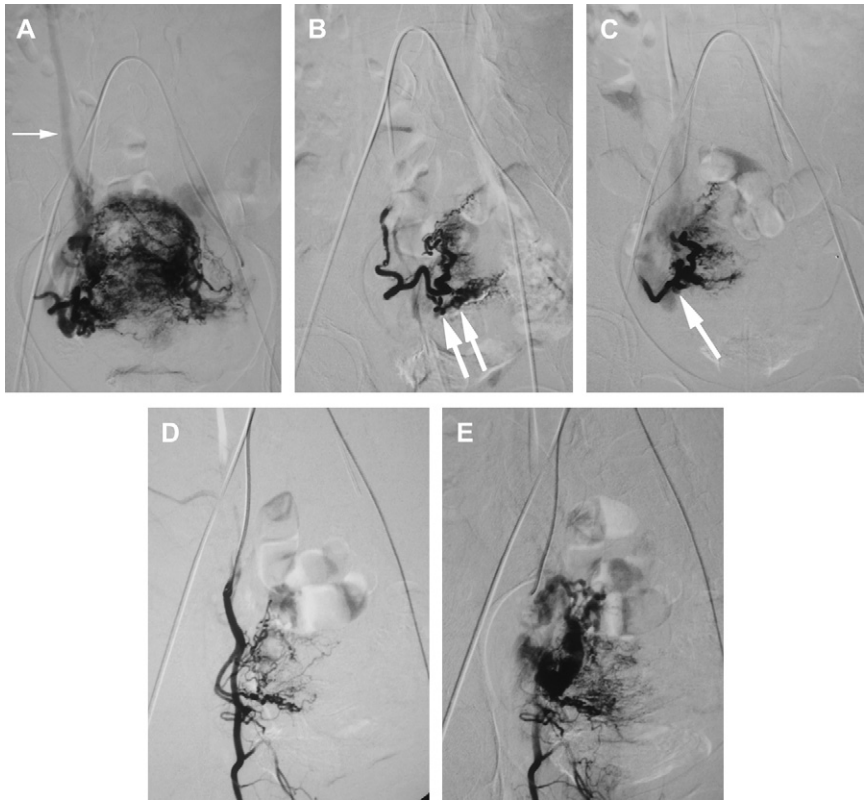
Uterine and adnexal arteriovenous malformation. (A) Twenty-four-year-old woman with recent miscarriage, dilatation, and curettage, complicated by severe bleeding and subsequent recurrent hemorrhage. Ultrasound examination showed hypervascular lesion in right cervical area with a differential diagnosis of either cervical pregnancy or arteriovenous fistula. Bilateral simultaneous anteroposterior arteriographic image reveals increased vascularity on the right uterus with an early filling right ovarian vein (arrow). (B) Right uterine arteriogram, early arterial phase in the left anterior oblique position. An enlarged cervicovaginal branch (arrows) supplied a hypervascular nidus on subsequent images. The position correlated with the cervical abnormality on duplex ultrasound (not shown). (C) Right uterine arteriogram in the left anterior oblique position after embolization. The cervicovaginal branch is occluded (arrow) and the arterial flow diminished. There is faint early opacification of veins in the right adnexae for uncertain reasons. (D) Arteriogram of anterior division of right hypogastric artery after embolization, revealing additional branches to the adnexae from other pelvic branches. (E) Late phase of arteriogram showing markedly enlarged veins extending laterally from the margin of the uterus into the adnexa. The uterine bleeding was controlled by the limited embolization of the cervicovaginal branch. The larger asymptomatic portion of the vascular malformation was asymptomatic and not treated. (From Roth AR, Goodwin SC, Vedantham S, et al. Management of gynecologic hemorrhage. In: Spies JB, Pelage JP, editors. Uterine artery embolization. Philadelphia: Lippincott Williams and Wilkins; 2005. p. 155; with permission).
